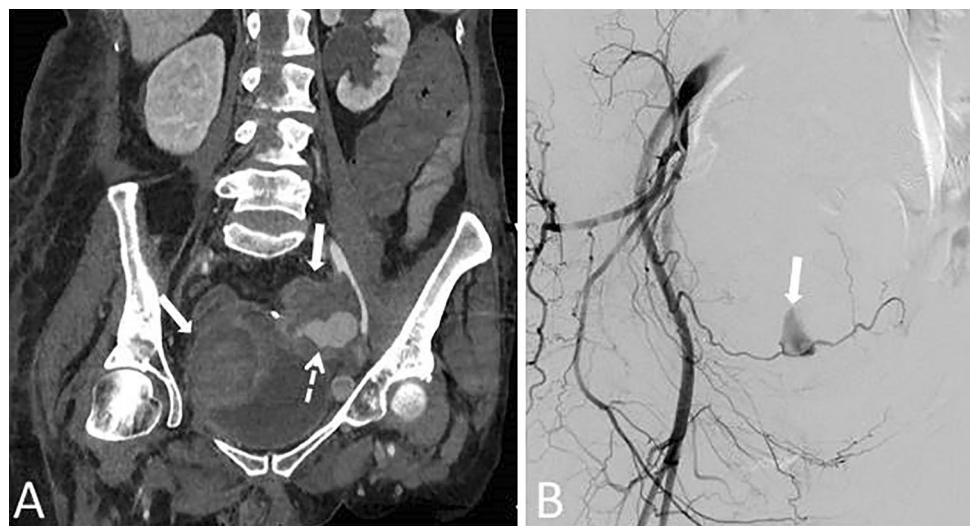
59-year-old female patient with recurrent endometrial cancer invading bladder wall and sigmoid colon. She now presents with abundant hematuria. A Coronal post-contrast CT image shows the pelvic mass (arrows) and active bleeding within it (dashed arrow). B DSA image delineates the superior vesical artery as the source of bleeding (arrow). Superselective coil embolization was performed to control active bleeding (not shown)
